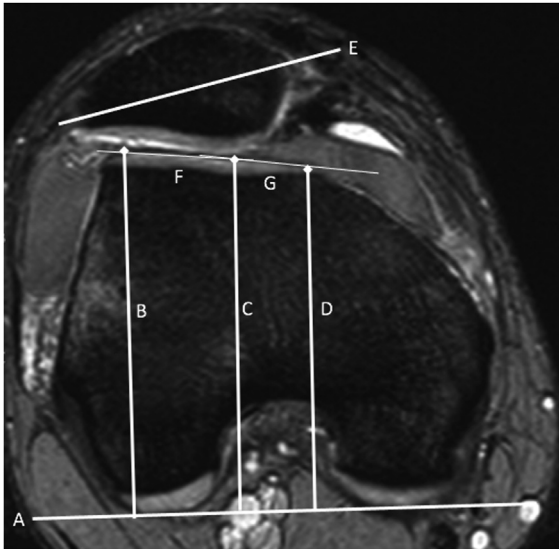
Axial magnetic resonance image depicting a Dejour C flat trochlea. Line A is a tangent along the posterior femoral condyles. Lines B, C and D are perpendicular to A and connect to the highest point of the lateral femoral condyle (B) and medial femoral condyle (D) and lowest point of the trochlea (C). Trochlear depth is $(B + D)/2 - C$. Sulcus angle is between the lines along the lateral trochlear facet (F) and medial trochlear facet (G). Patellar tilt is the angle between line A and the line along the maximum width of the patella (E).
